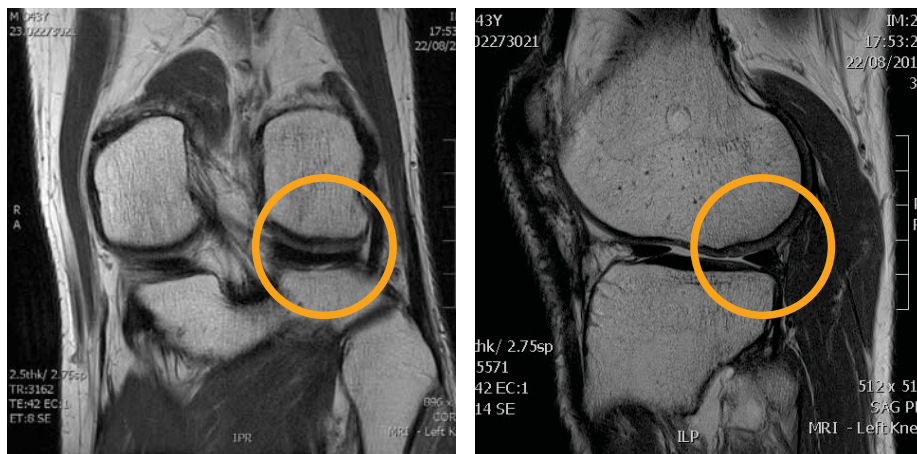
A large cartilage and bone defect is evident on the pre treatment MRI. Following ACI treatment the MRI demonstrated remodelling of the bone and infill of the cartilage defect. Reduced bone bruising is also evident.
